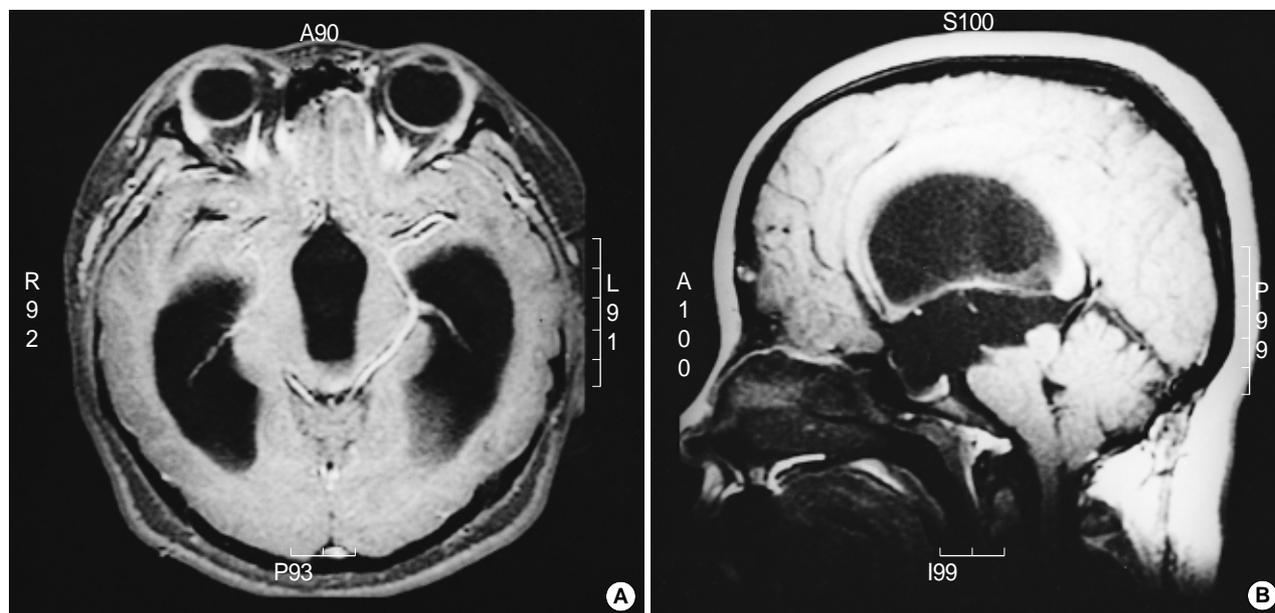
Axial T₁-weighted MRI after gadolinium administration (A) and sagittal (B) T₁-weighted MRI demonstrate marked noncommunicating hydrocephalus due to aqueductal stenosis without any tumorous lesion.
